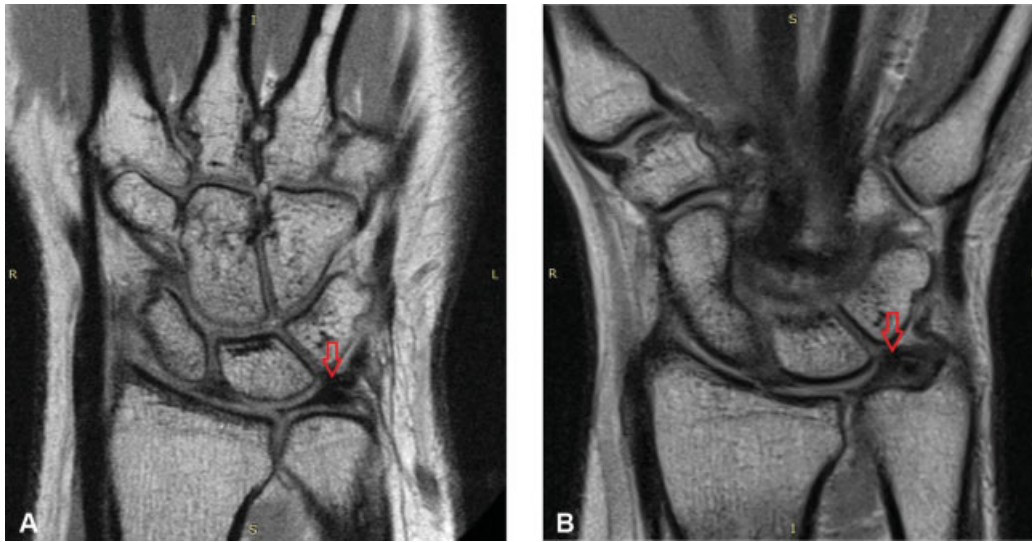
Lunotriquetral ligament: dedicated extremity MRI (A) versus conventional MRI (B).
